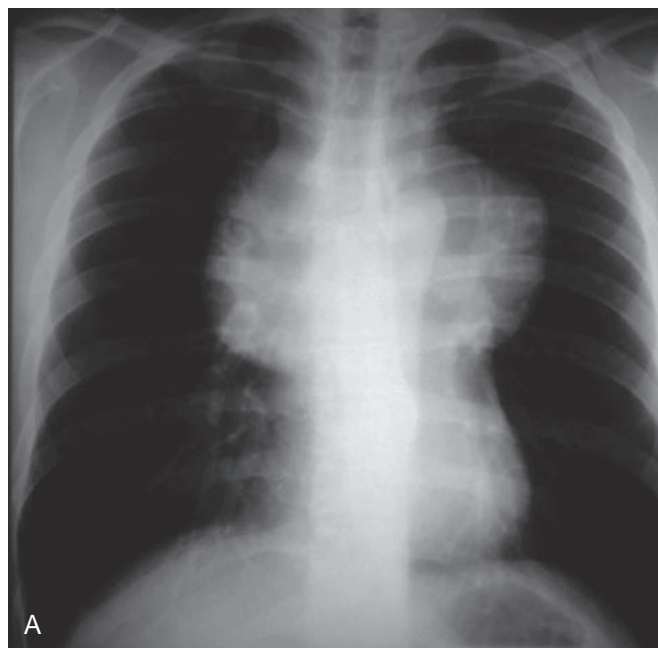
A, Chest radiograph demonstrating a large anterior mediastinal mass. B, Computed tomography scan demonstrating a large anterior mediastinal mass.
